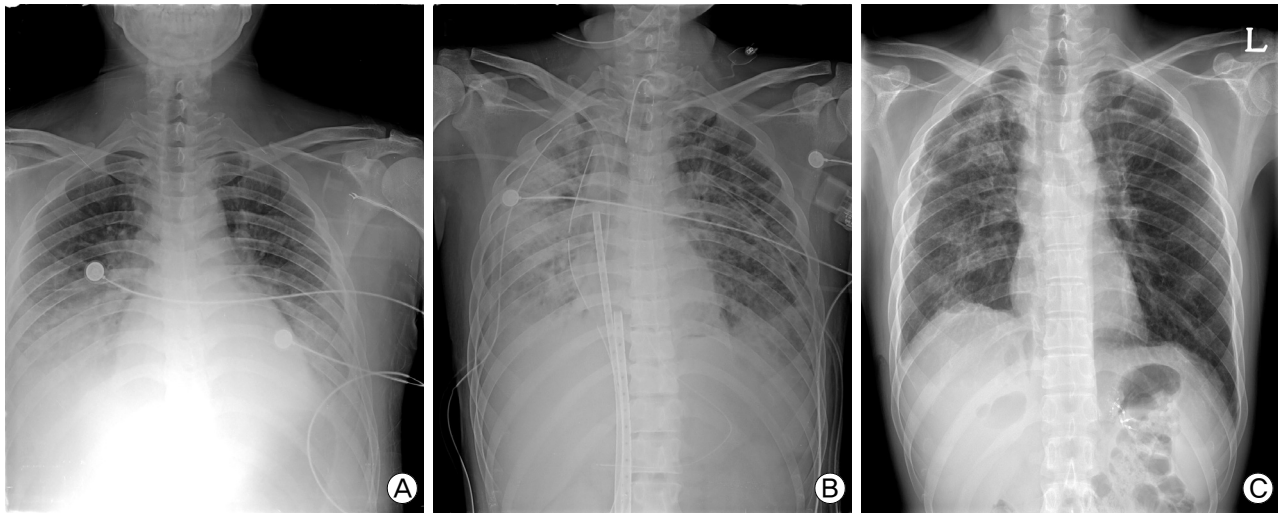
Chest radiographs initial, extracorporeal membrane oxygenation (ECMO) cannulation, discharge. (A) Initial chest X-ray with dyspnea, patient not intubated with high FiO_2 by facial mask. (B) chest X-ray after ECMO cannulation. (C) chest X-ray at discharge.
